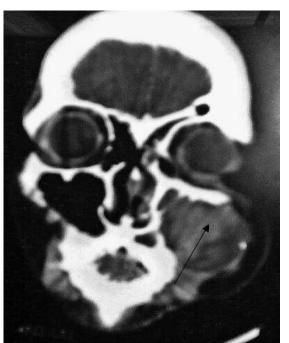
I Coronal CT image of the paranasal sinuses shows a large soft tissue mass within the left maxillary sinus (arrow) extending superiorly into the left ethmoidal sinuses and inferiorly into the ipsilateral superior alveolar process. Medially, the mass extends into the nasal cavity and is in close contact with the bony nasal septum.
